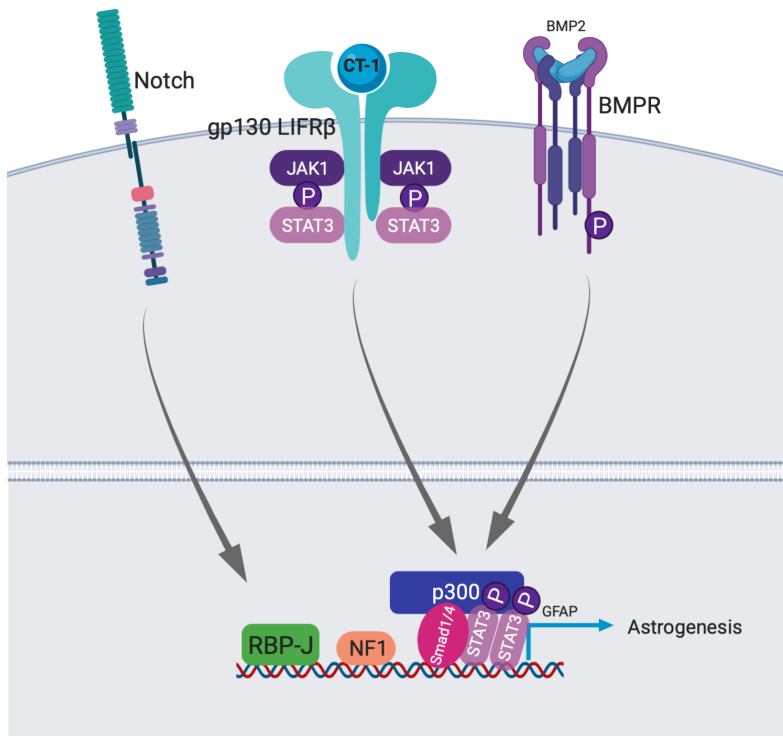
Synergistic pathway of Notch signaling, BMP family signaling, and IL-6 signaling in conjunction with the activated JAK-STAT pathway to induce astrogenesis. First, CT-1 binds to gp130/LIFRB coreceptors, which induces downstream signaling via the JAK-STAT pathway molecules. Together, it forms a complex with downstream BMP signaling molecules. At the same time, Notch is activated and cleaved, and translocate to the nucleus to interact with RBP-J to form another transcriptionally active complex. Along with NF1, the two complexes bind to the GFAP promoter.
